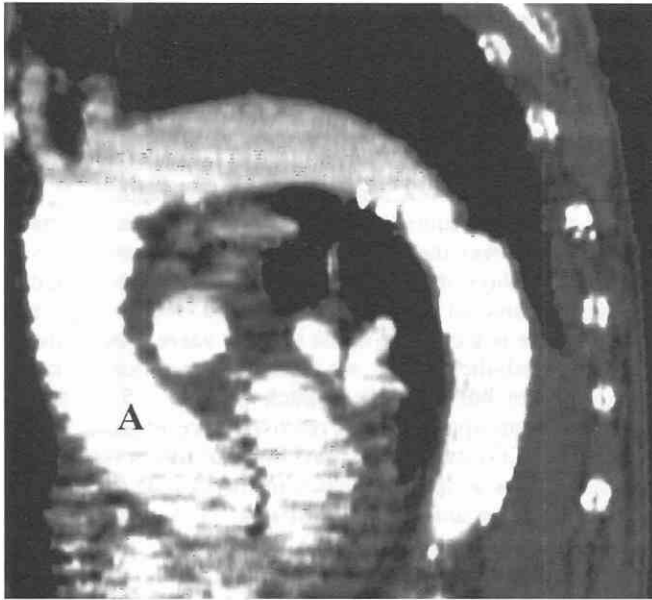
Sagittal multiplanar reconstruction CT scan of the thoracic aorta in a patient with suspected pulmonary embolism. Note the prominent cardiac pulsation artifacts. A = aorta.
